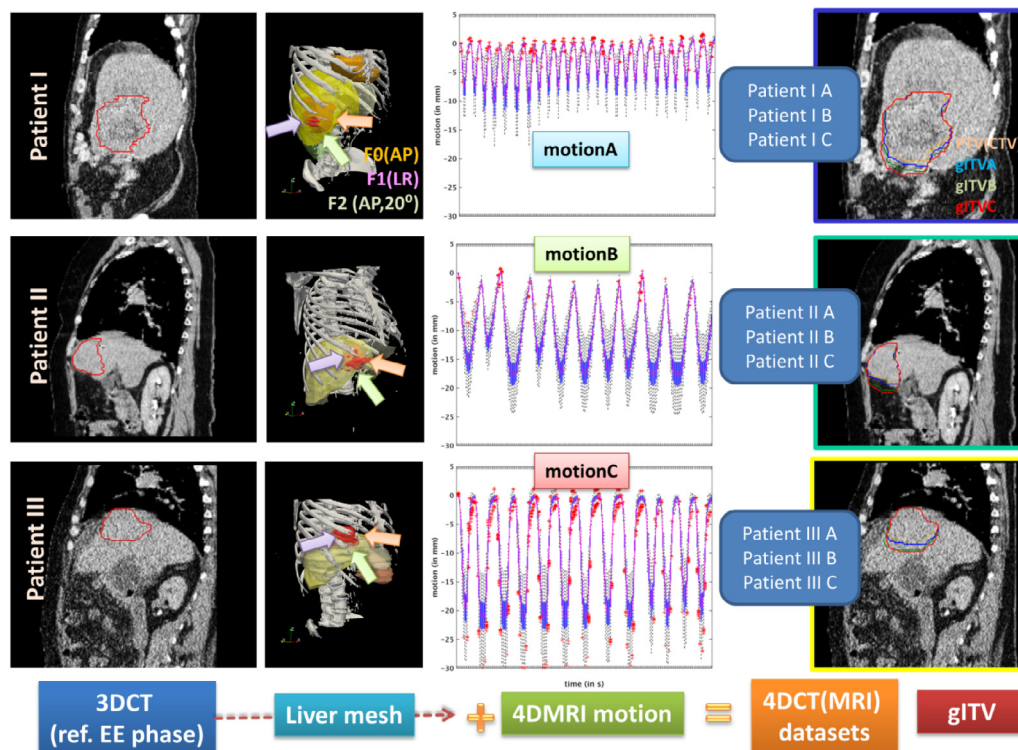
Components used for generating 4DCT(MRI) datasets for 4D dose calculations.
